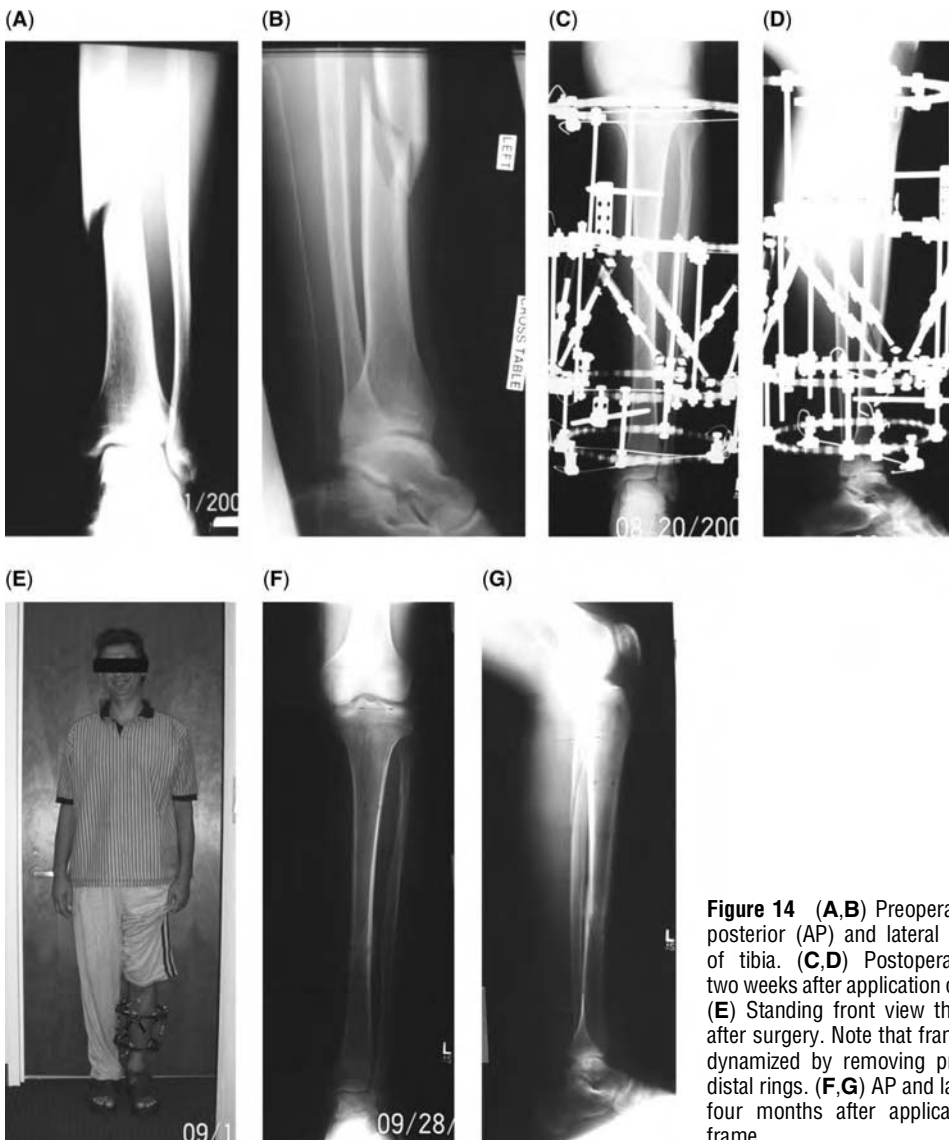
(A,B) Preoperative antero-posterior (AP) and lateral X-ray views of tibia. (C,D) Postoperative X-rays two weeks after application of the frame. (E) Standing front view three months after surgery. Note that frame has been dynamized by removing proximal and distal rings. (F,G) AP and lateral X-rays four months after application of the frame.
